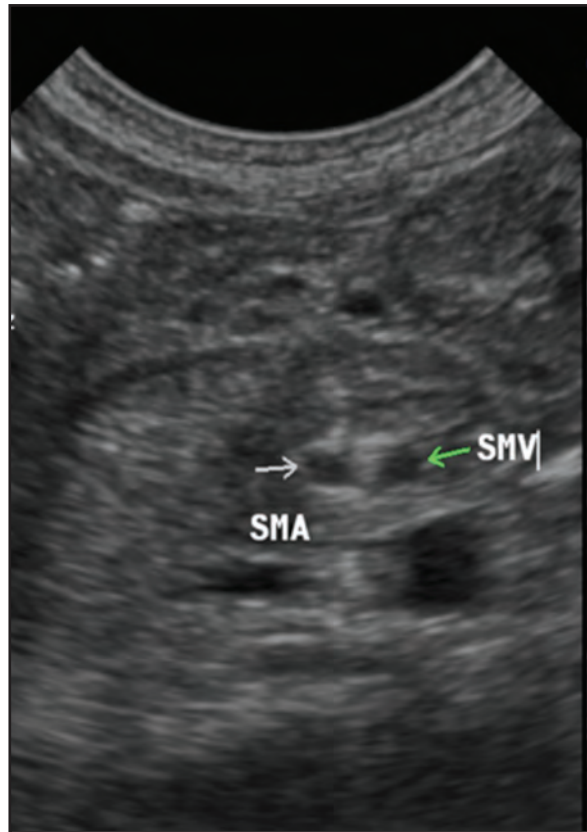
Ultrasound in axial plane showing the reverse superior mesenteric artery (SMA) and superior mesenteric vein (SMV) orientation
